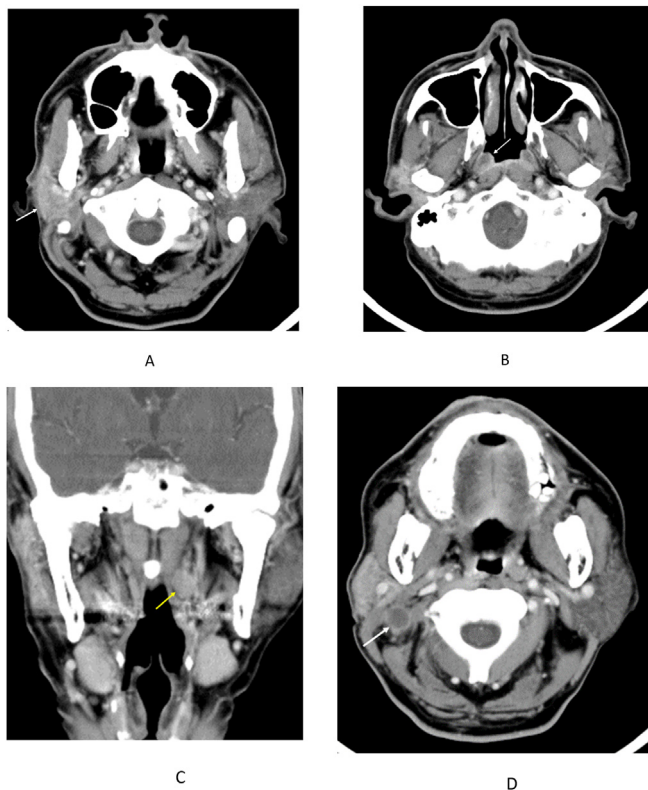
(A) Contrast-enhanced axial computed tomography (CT) showed diffuse contrast enhancement of the small, post-surgical right parotid gland (arrow). (B) Contrast-enhanced axial CT revealed a subtle and protruded lesion in the right torus tubarius (arrow). (C) Contrast-enhanced coronal reformatted CT demonstrated an enlarged lymph node in the left retropharyngeal space (arrow). (D) Contrast-enhanced axial CT indicated an enlarged and necrotic lymph node in the right neck level II region (arrow).
